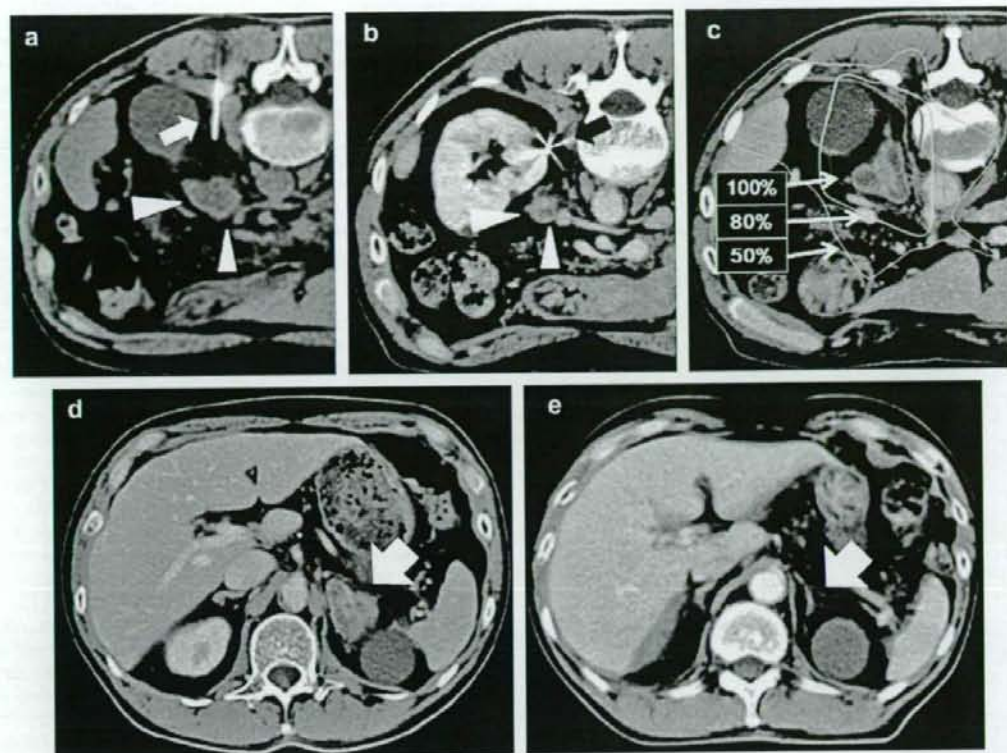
Patient (No.8) with the left adrenal metastatic tumor treated with RTRT. There was an incidental left renal cyst near the tumor. (a) The fiducial gold marker was implanted near the left adrenal tumor (arrowhead) using a percutaneous approach. The 18-Gauge needle used for gold marker implantation (arrow) is visible in the CT image. (b) Implanted gold marker (arrow) was seen near the left adrenal tumor (arrowhead). (c) Radiation treatment plan. Red line showed 100% isodose line, aqua line 80%, and orange line 50%. (d) Tumor (arrowhead) as seen before RTRT. (e) Tumor had disappeared 12 months after RTRT with dose of 48 Gy in eight fractions.
